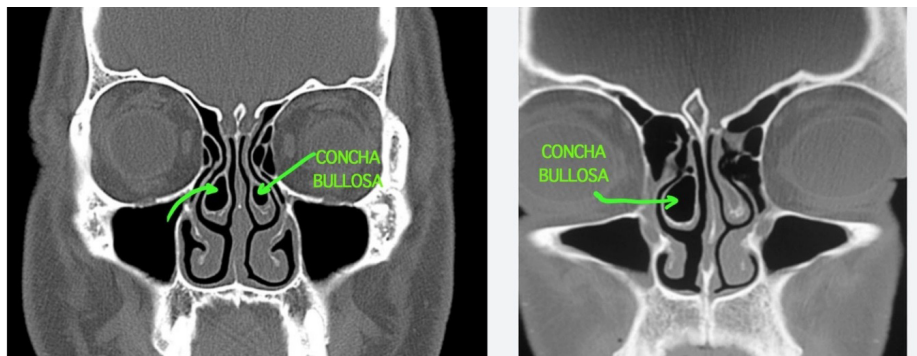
Nasal CT scan of the patient had a concha bullosa.
